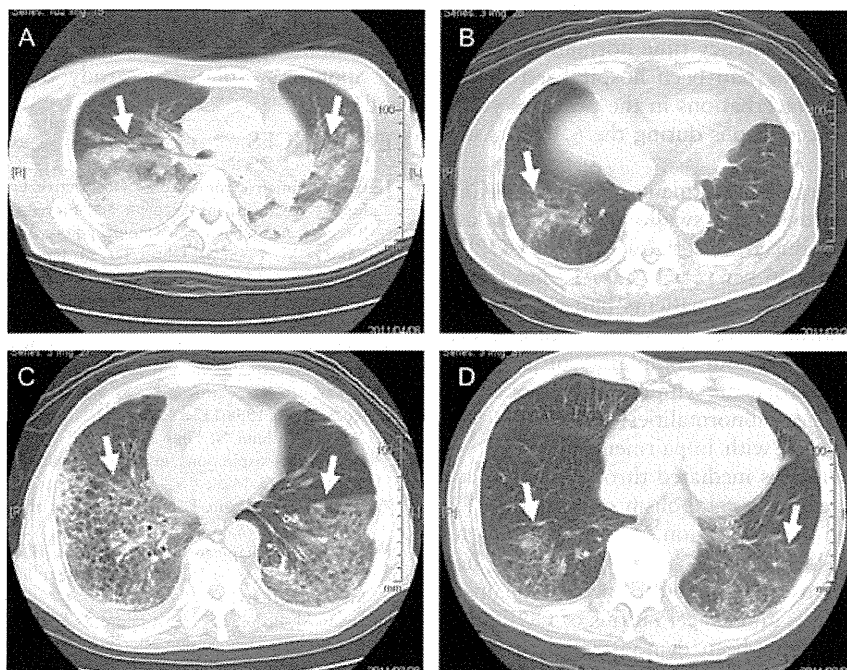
Chest computed tomography scans of four randomly selected individuals showed that the consolidation was distributed prominently in the lower part or back of both lungs (A, C, D) or in one lung (B).
